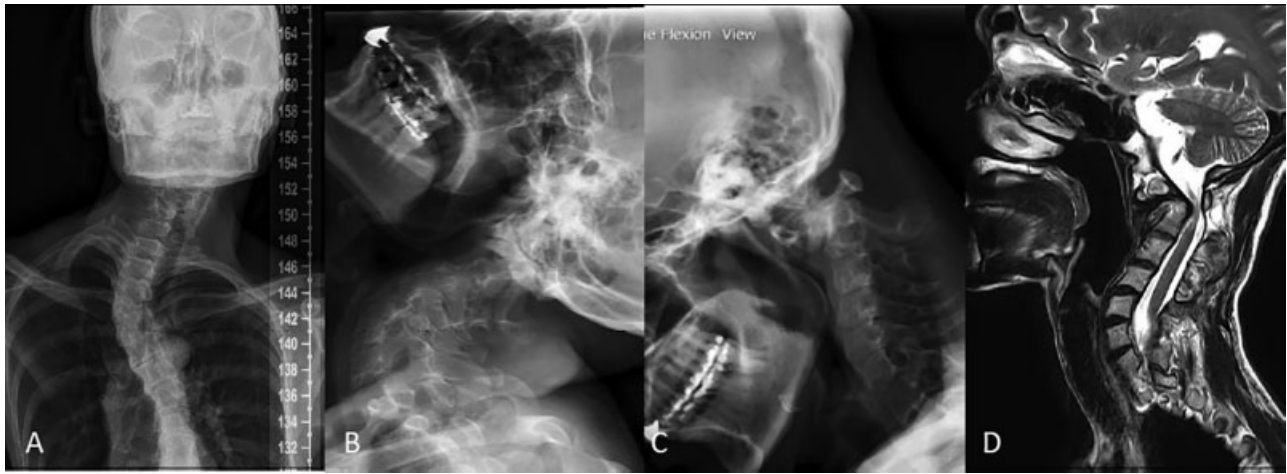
Image of first case, severe deformity of cervical spine, with C1–2 subluxation. (A) C-spine AP view. (B) C-spine extension view. (C) C-spine flexion view. (D) MRI T2 sagittal view showed stenosis at C2 level. AP, anteroposterior; MRI, magnetic resonance imaging.
